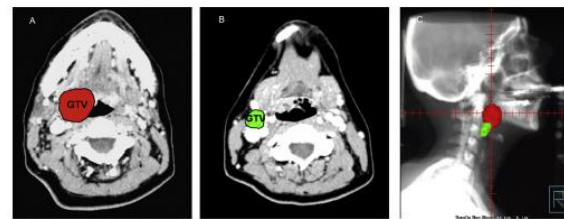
T2 N1 M0 sample tonsil cancer. Panels A and B depict representative CT images through the tonsil and nodal GTV respectively. Panel C shows lateral radiograph with tonsil GTV (red) and nodal GTV (green).
